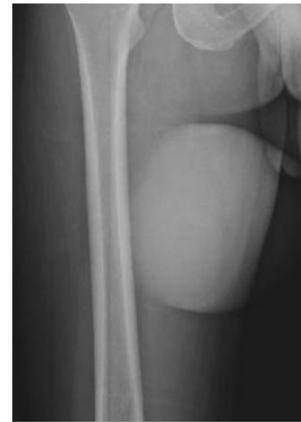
AP radiograph of the right thigh
